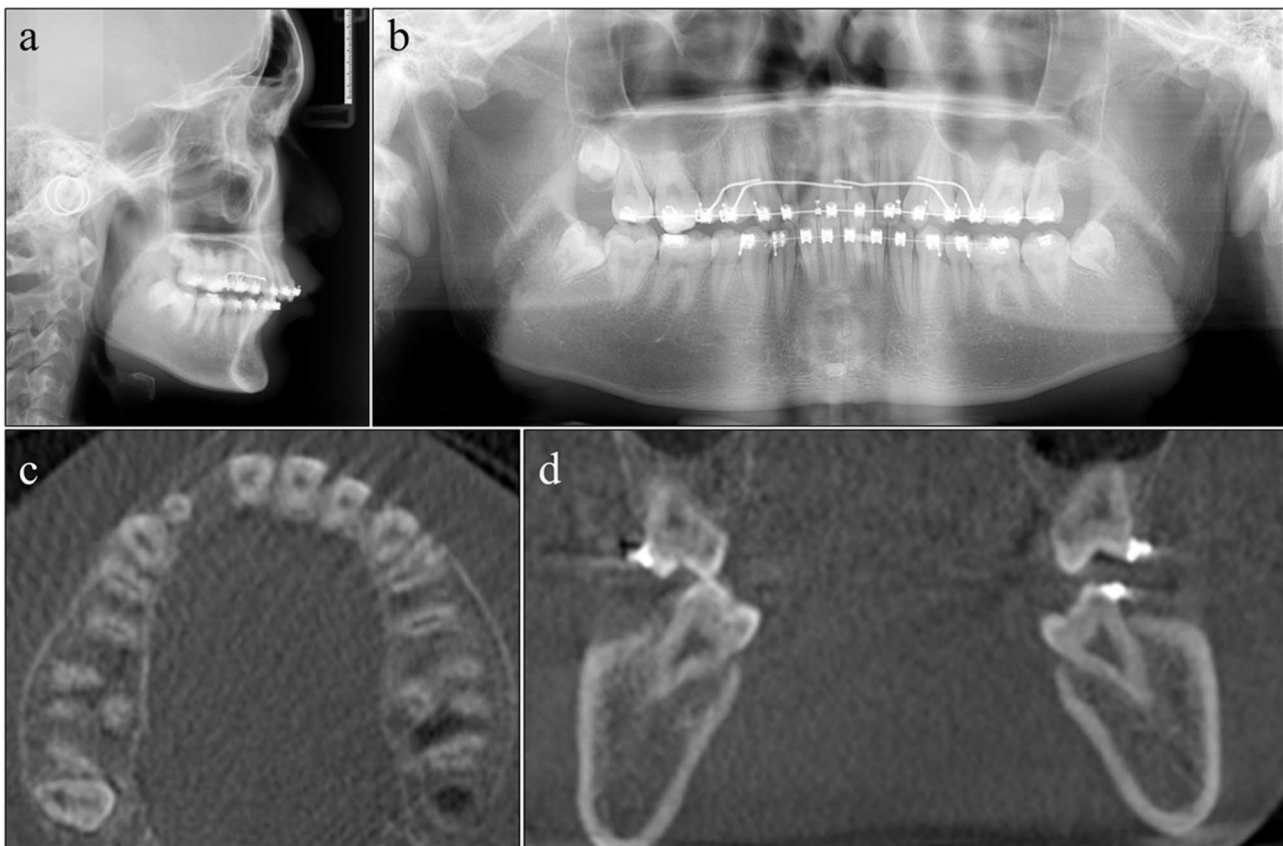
Pre-retreatment lateral cephalogram, panoramic radiograph and CBCT. (a) Lateral cephalogram. (b) Panoramic radiograph. (c-d) CBCT. An axial slice revealing bone presence at the alveolar cleft bone graft site, located distally to the right maxillary central incisor (indicated in c), and a coronal slice at the level of the second molars showing significant discrepancies in the width of posterior teeth bilaterally (indicated in d)
